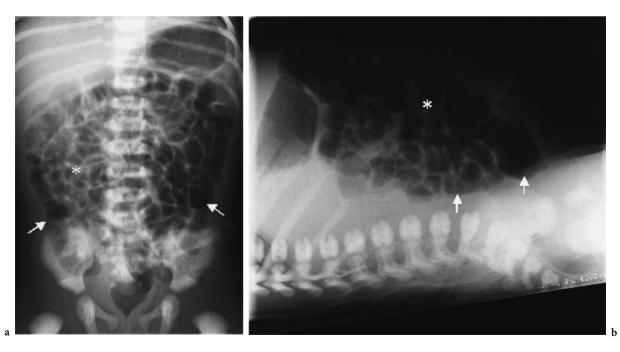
Normal radiographs of abdomen in an infant with anatomic position and normal intestinal gas distribution. Peripheral (AP) low (lateral) location (*single arrow*) depicts colon; *asterisk* depicts small bowel
